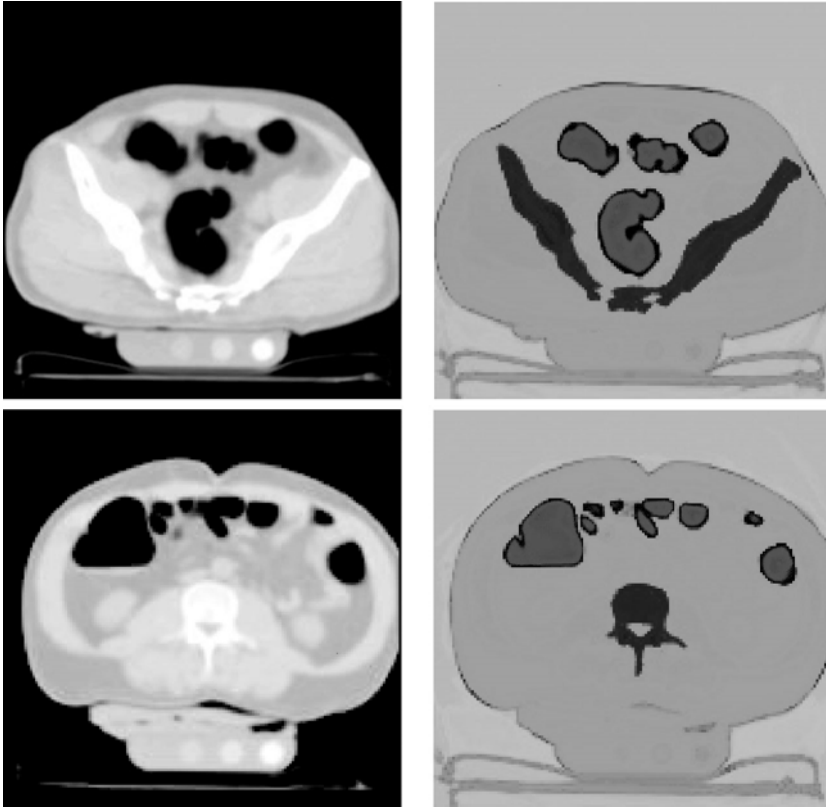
Two axial slices from a CT volume placed on the fcc grid and the corresponding 4-segmentations. (All four images were interpolated to the sc grid for display purposes.)
